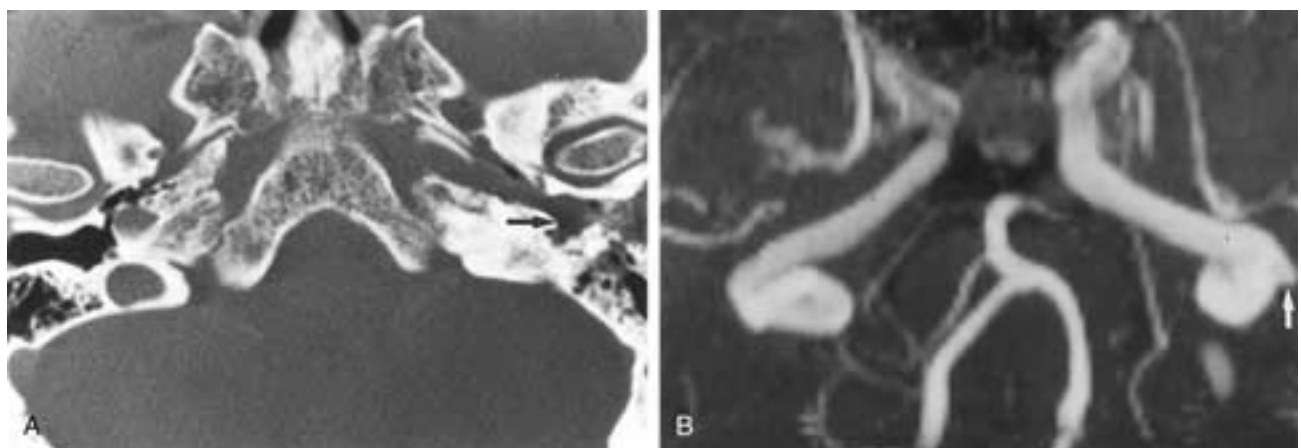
Left aberrant carotid artery after needling. A, High-resolution CT shows an aberrant artery (*arrow*) coursing through the left tympanic cavity to enter horizontal carotid canal through a dehiscence in the carotid plate. Note the packing material in the external auditory canal for hemostasis. B, MRA 3D time-of-flight technique, maximum intensity projection, shows a false aneurysm (*arrow*) in its intratympanic segment, confirmed by selective catheter angiography.
